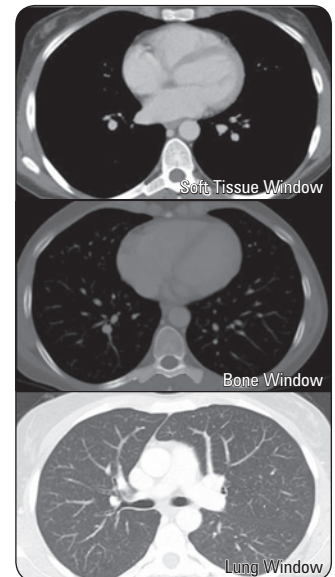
CT thorax windows
